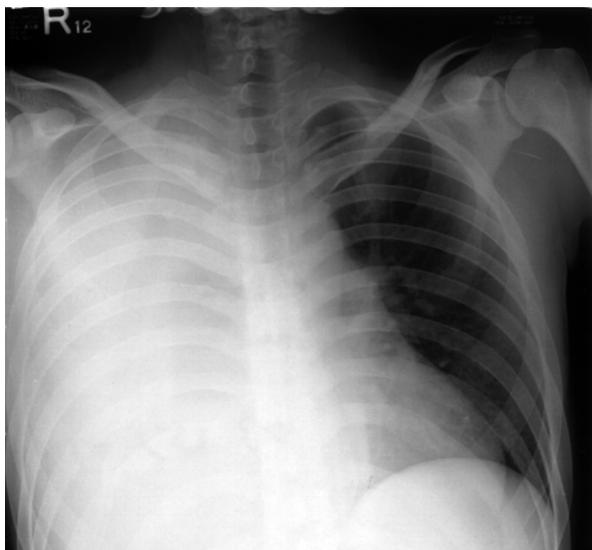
Chest plain film showing total opacification in the right-side lung field.
